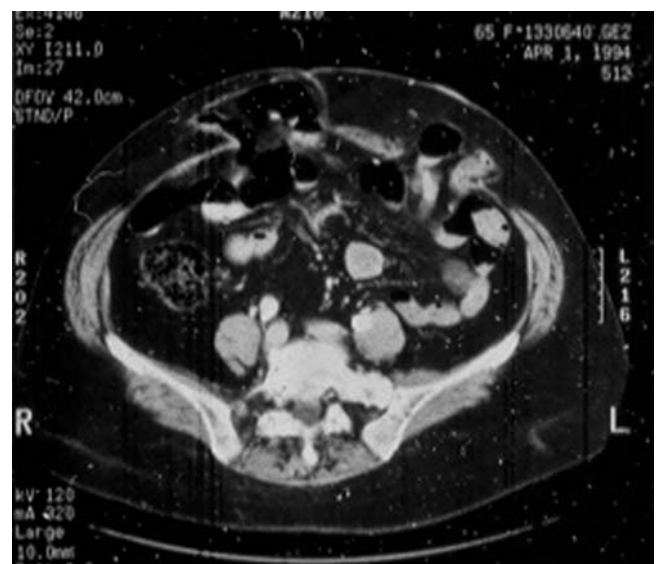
Abdominal CT scan demonstrating a large parastomal hernia with a concomitant incisional hernia.
